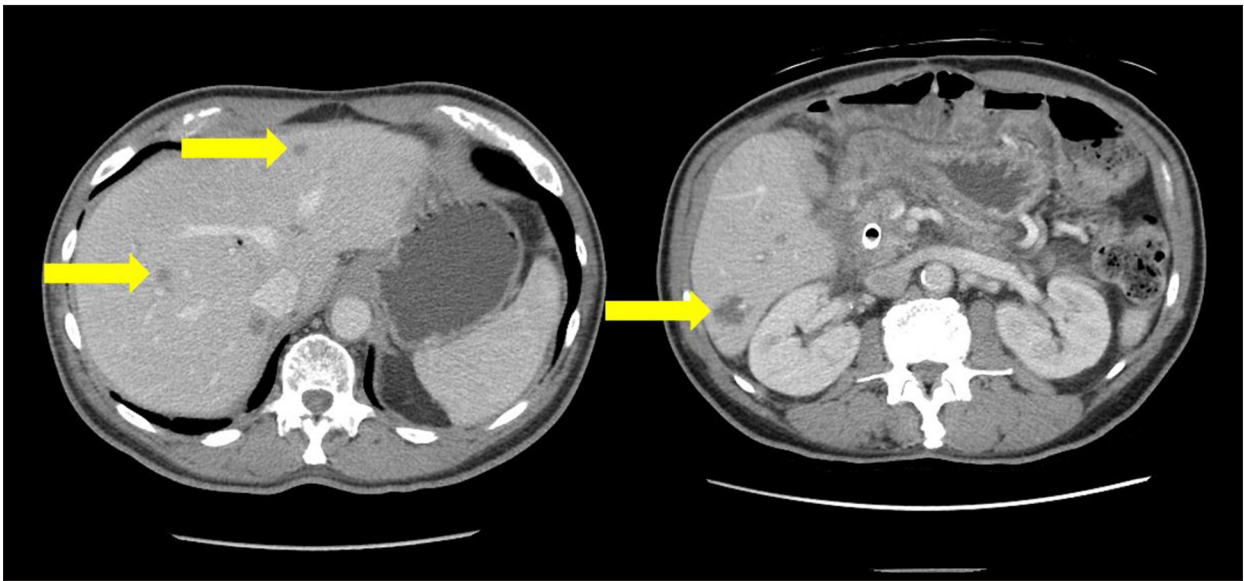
Computed tomography scan of the abdomen performed before starting immunotherapy showing multiple hepatic lesions consistent with pancreatic cancer metastases as shown using the arrows.
